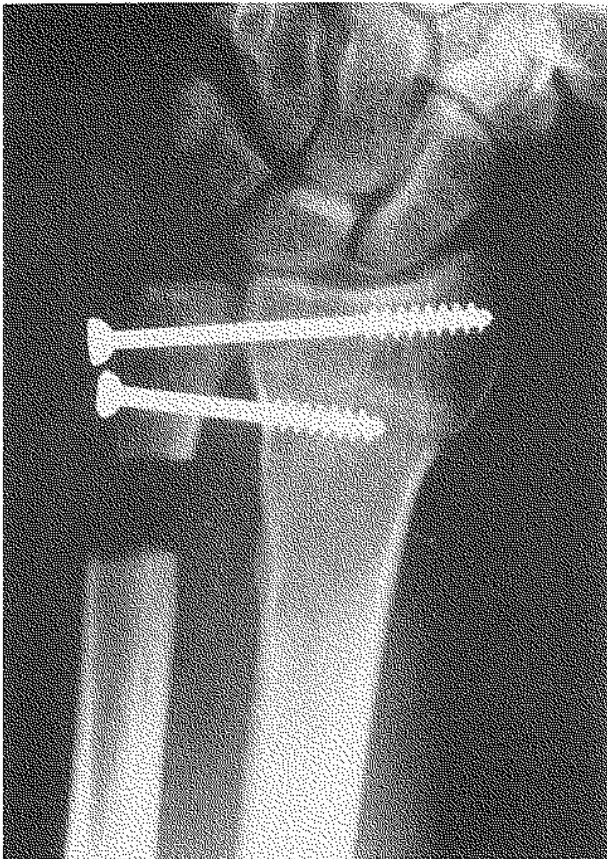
Radiograph of a Sauvé Kapandji procedure.
